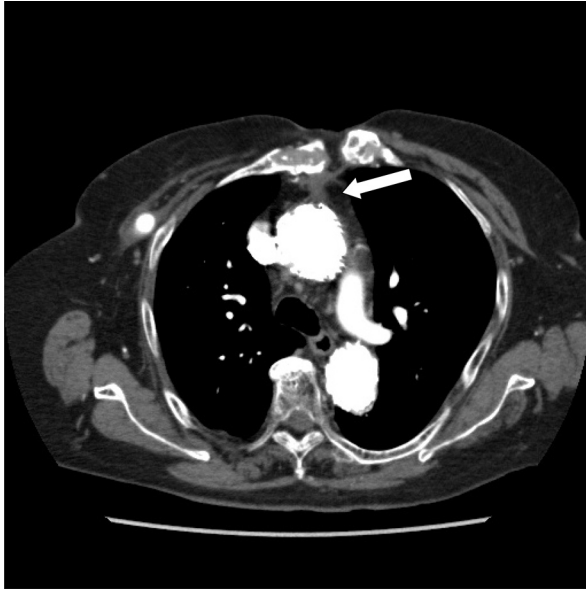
A postoperative axial computed tomography (CT) image shows the reduction of the ascending aortic pseudoaneurysm (arrow).
